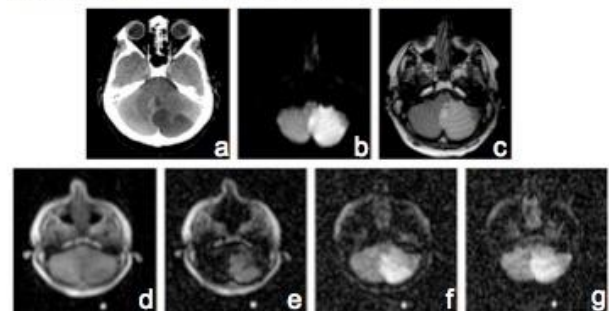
CT, 3T MRI and FFC MRI images from a 50 year old male admitted with a posterior inferior cerebral artery territory infarct. a) CT at 24 hours after onset, b) 3T DWI image at 96 hours after onset c) 3T T2 weighted image at 96 hours after onset d-g) FFC-MRI inversion-recovery images at the level of the lesion at 200mT, 2.2mT, 2mT and 0.2mT respectively (90 hours after onset).
